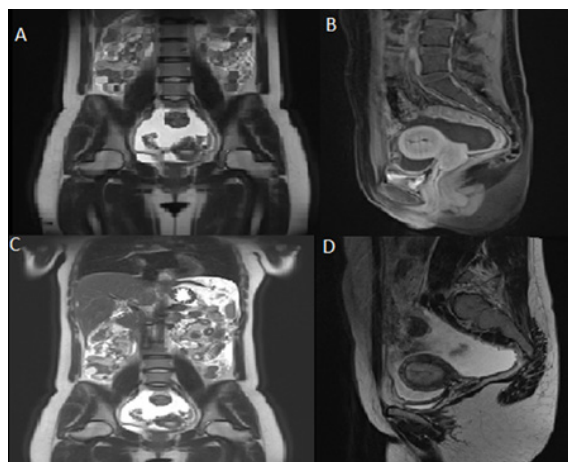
ABDOMINAL MRI: THE T2-WEIGHTED SEQUENCE (A) SHOWS HYPERINTENSITY IN THE PELVIC REGION, WHICH IS CONSISTENT WITH THE FINDINGS ON THE DIXON (B), HASTE (C), AND TSE (D) SEQUENCES, SUGGESTING FREE FLUID IN THAT AREA; HOWEVER, NO LESIONS CHARACTERISTIC OF TUBERCULOSIS OR OTHER PELVIC MORPHOLOGICAL ABNORMALITIES ARE EVIDENT.
